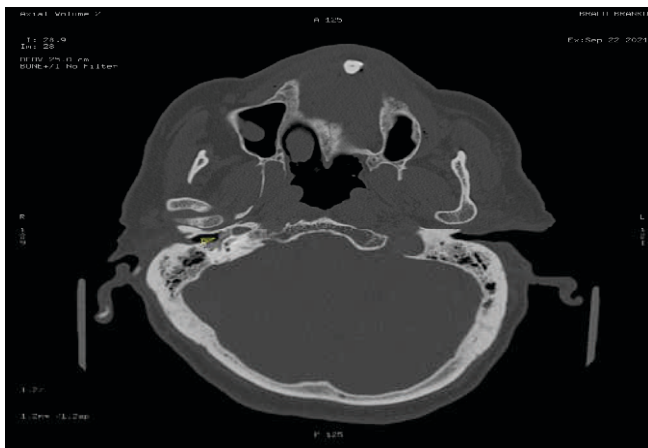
The finding of temporal bone CT. The density of the foreign body in the middle ear was noted in coronal view.
